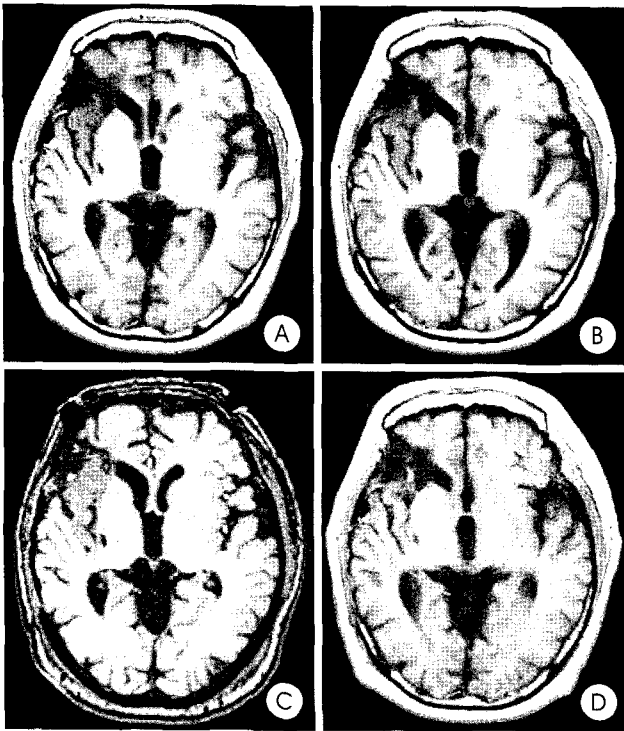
A : Precontrast brain magnetic resonance(MR) imaging showing a low signal lesion on the right temporal cortex after resection and external radiation. B : Precontrast MR image, 28 months later, showing gyral thickening, which is considered a recurrence. C : T1-weighted MR image on the day of Gamma Knife radiosurgery(GKS). D : Eight months after GKS, follow-up MR image showing significant gyral shrinkage.
